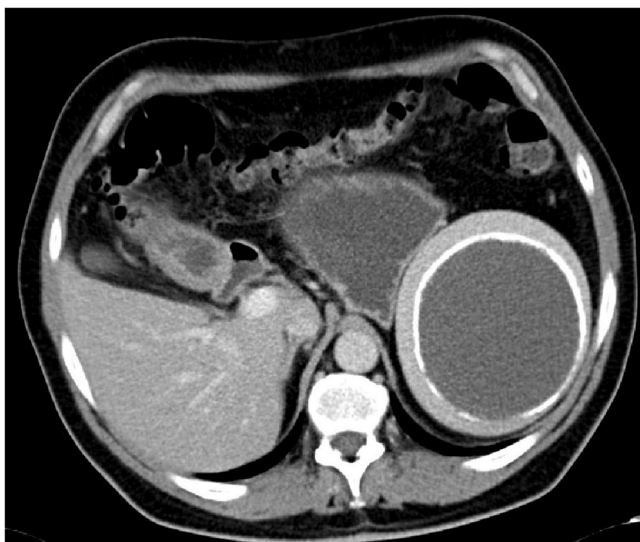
CT slice of the splenic cystic lesion with dimensions of 8.7 × 9.5 × 11 cm, with a thick calcified wall.
